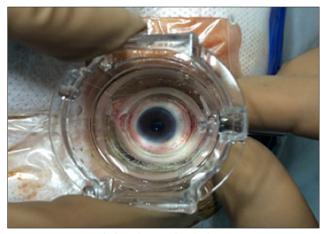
Eye exposure before ultrasound cycloplasty.
